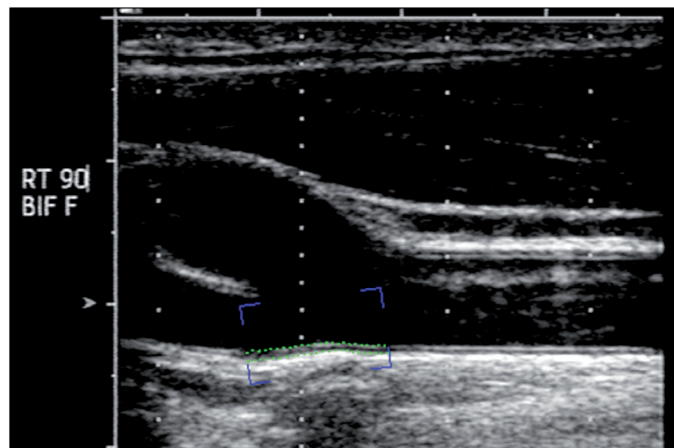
Representative example of a longitudinal, cross-sectional carotid ultrasound image of a 62-year old male patient (a). The blue box shows an example of a region of interest for computer aided edge detection (green dotted lines). The distance between the green lines represents the IMT.
